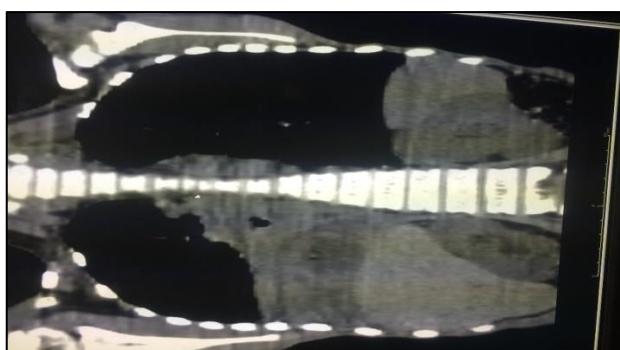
(A): CT thorax of right middle consolidation.
